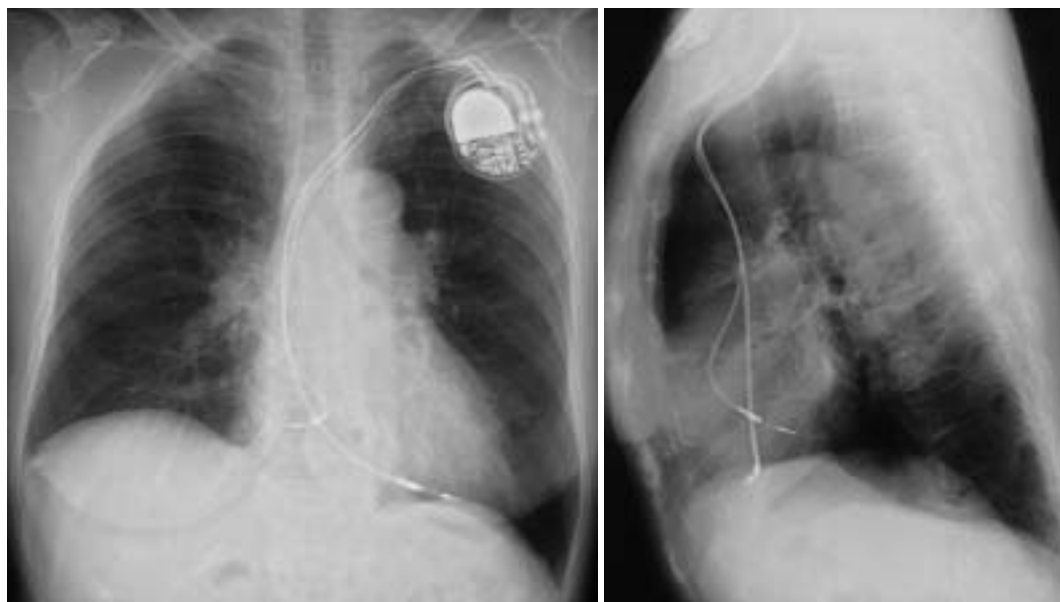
Postoperative chest radiographs
